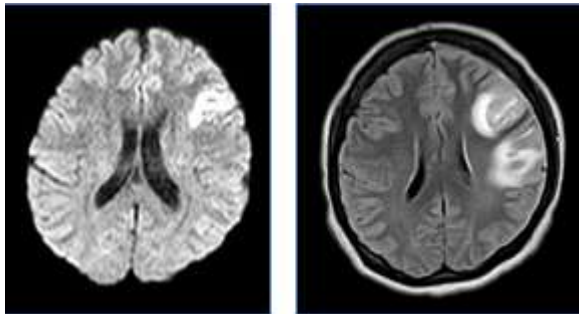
and Figure 2: DWI and Flair images showing blooming in multiple areas of left frontal lobe suggestive of acute venous infarct.
